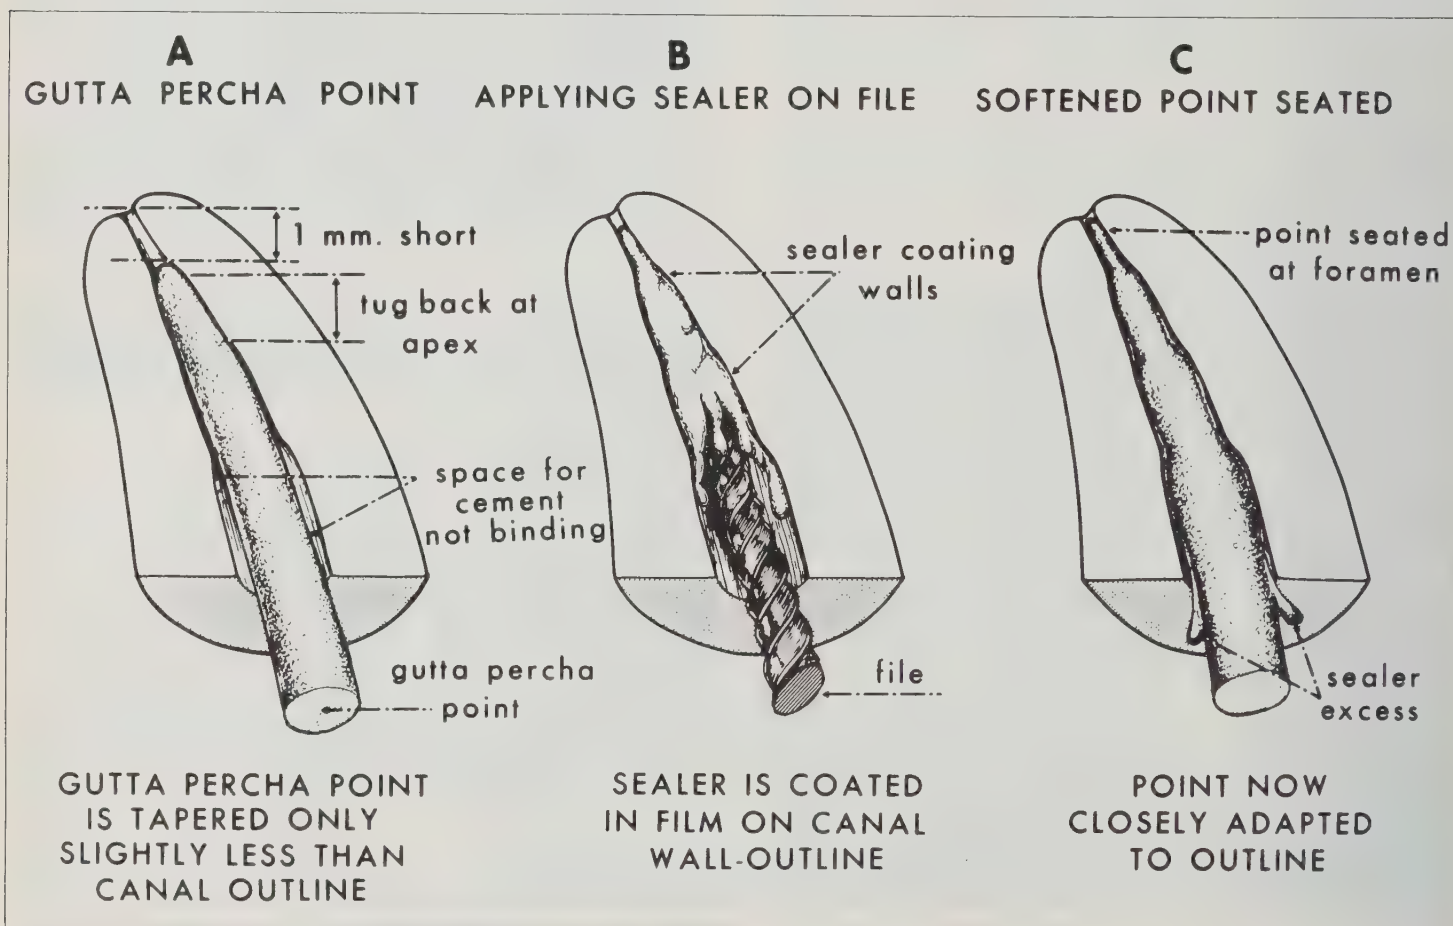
(A) A master cone gutta percha point is trial fitted so that tugback occurs slightly short of the prepared apical foramen. Proper shaping of the tapered canal insures only a slight space for cement coronal to this region. If the point fits exactly to or beyond the radiographic apex, it is intentionally cut back about 1 mm short. (B) The last size file, which will reach the apical foramen, is used to coat a film of sealer along the walls of the canal, taking care to carry sealer as close to the foramen as is possible. (C) After the gutta percha point is softened in the apical 2 to 5 mm end in a solution of chloroform and rosin, it is seated to the apical foramen by firmly pressing it to full working length. A direct apical impression is made of the apical canal, while sealer excess coats the canal walls and flows into lateral canals during subsequent coronal canal condensation.
